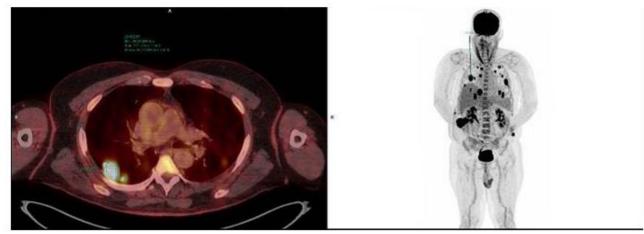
Initial PET-CT of September 5 of 20015 showing mulyiple lung lesion with avidity for FDG.
